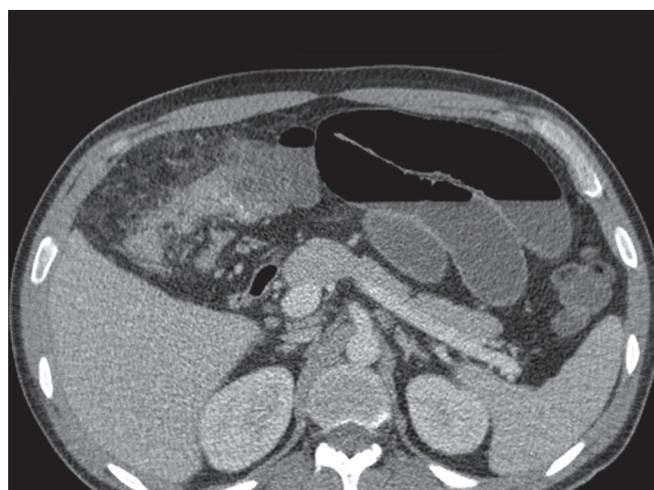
Abdominal CT showing a 5 cm colonic stenosis at the hepatic angle, with fistulous trajectories and an increased fat tissue, resulting in intestinal occlusion.
